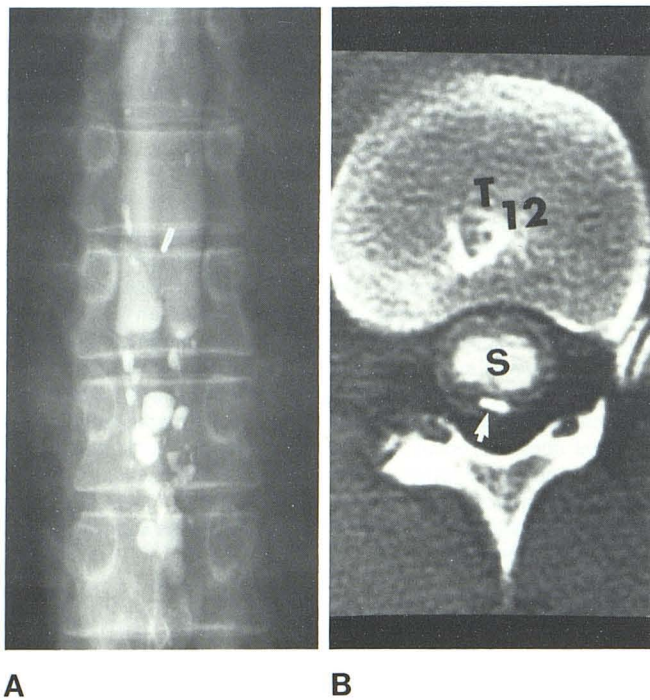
Case 2. Block and syrinx with arachnoiditis in 48-year-old man with progressive leg weakness over several years. A, Metrizamide myelogram with C1–C2 puncture. Irregular complete block at T9. Residual Pantopaque below block. B, CT scan at T12. Contrast material within syrinx (s) extends from T9 to conus. Note low-density rim of cord and thickened arachnoid surrounding syrinx. High density posterior to cord (arrow) represents ossification, or so-called arachnoiditis ossificans, proven at surgery.
